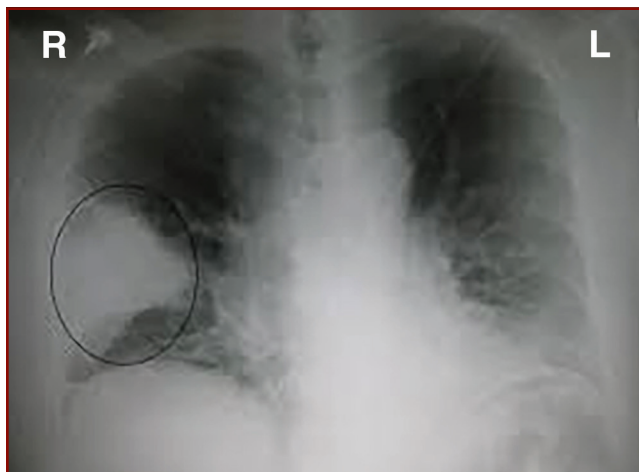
Standard x-ray shows area of infiltrate in the lower right lobe of the lung. In the figure, evidence of pneumonia can be seen on the right lower lobe of the lung.
